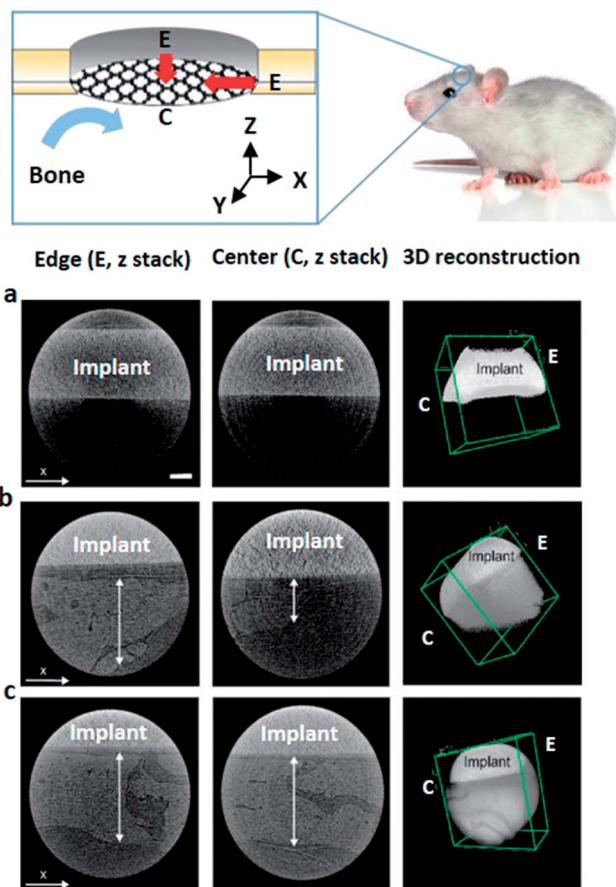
Synchrotron X-ray images of regenerated bones on (a) CP Ti, (b) RGO-CP Ti, and (c) Dex/RGO-CP Ti after 8 weeks (scale bar = 200  $\mu$ m). Vertical arrow indicates bone thickness (z-axis fixed, z-stacked image of edge part (left column) and central part (center column) of regenerated bone on the implant).
